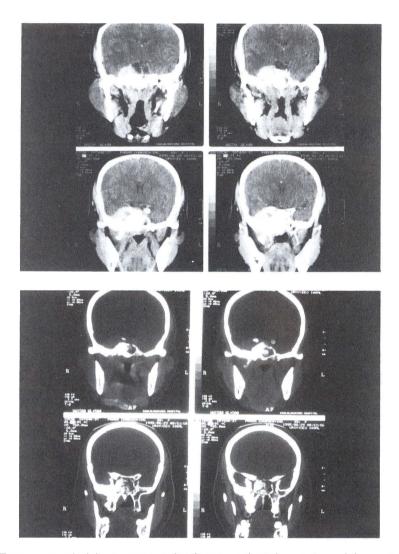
A: CT scan revealed homogenous isodense, enhancing extra-axial mass at right middle cranial fossa, sphenoid sinus and nasopharynx.
